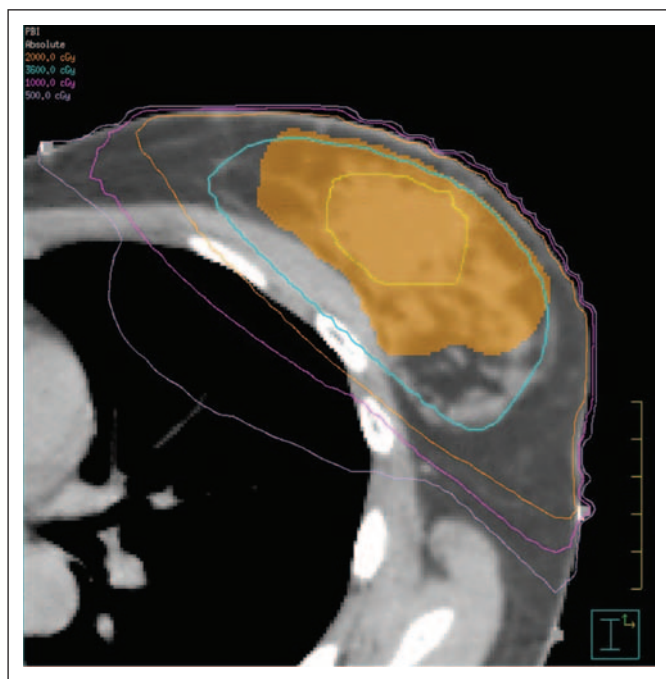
Dose distribution showing 36-Gy (blue), 20-Gy (orange), 10-Gy (purple), and 5-Gy (lavender) isodose lines superimposed on planning computed tomography (CT) for a patient treated with mixed photon-electron technique at Beth Israel Deaconess Medical Center. Yellow line, excision cavity; orange color-wash, planning target volume. The ipsilateral lung volumes were: ipsilateral lung volume (ILV)-20 Gy, 0%; ILV-10 Gy, 2%; and ILV-5 Gy, 11%. The contralateral lung was not exposed.
